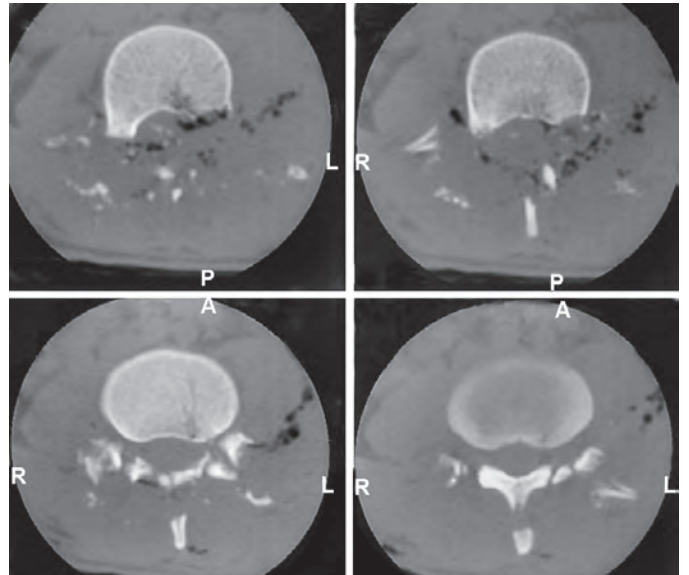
CT showing injury to posterior elements
